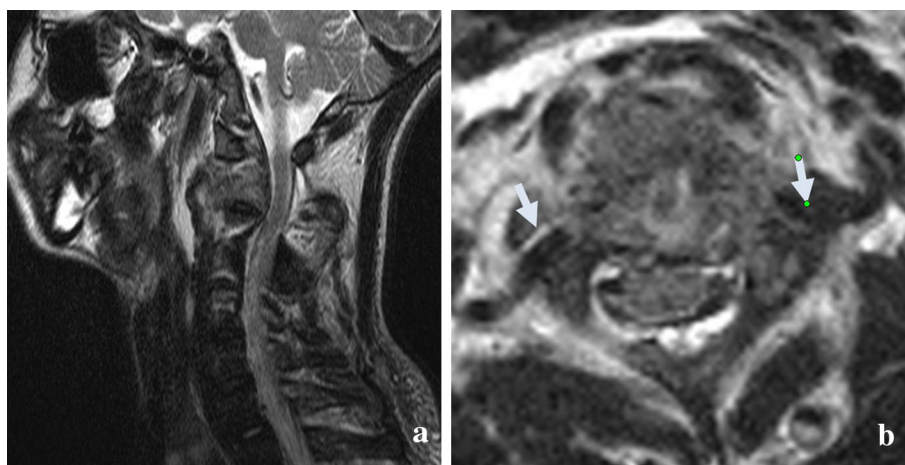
a T2-weighted MRI of cervical spine in the sagittal plane demonstrated neoplasm involving both C2 and C3 vertebral body, the C2 collapse for pathologic fracture and expand around, with a long T2 signal in the front of C2–4 indicating bleeding. b The T2 axial image
